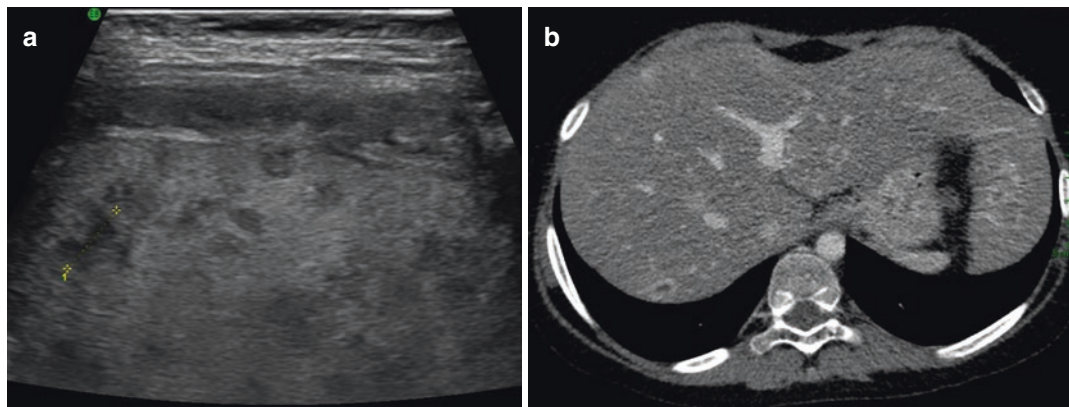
Candidiasis in children treated for acute leukemia. (a) Multiple hypoechoic nodules on US exam. (b) On CE-CT hypodense liver nodules with thin rim enhancement (arrows)
